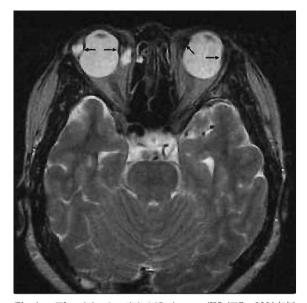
T2-weighted axial MR image (TR/TE=3800/120 msec) shows a markedly expanded buckle element surrounding the right globe, which is hyperintense with a low signal intensity rim. Note the contour deformities of the medial and lateral surfaces of the bilateral globes secondary to the encircling scleral buckles (arrows). Retinal detachment in the contralateral eye treated with an encircling silicon band.
